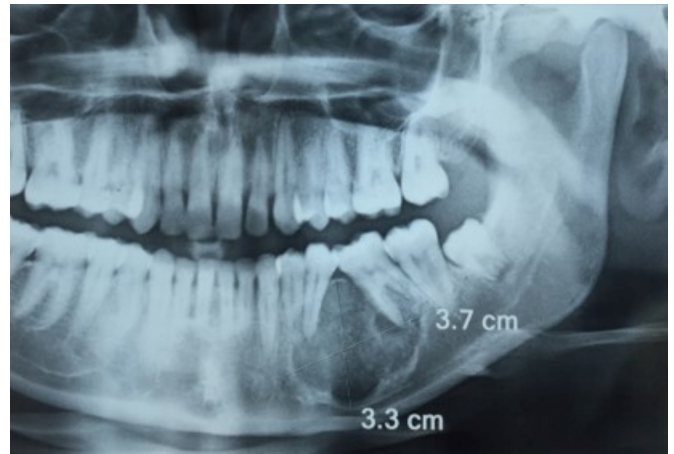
Cropped panoramic radiograph showing the lesion's size (3.7x3.3 cm).
